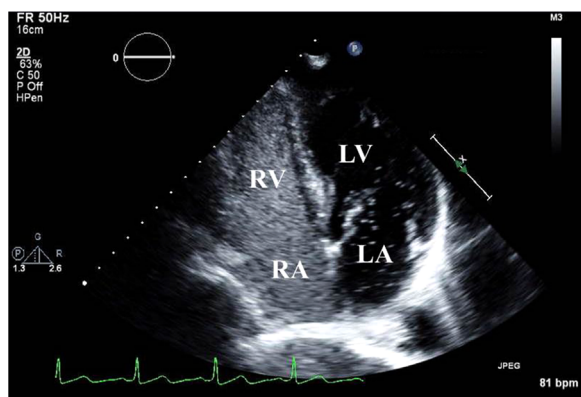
Example of positive contrast study by TTE in a patient with PFO. Microbubbles are visualized filling the right-sided chambers and into the LA and LV. LA, left atrium; LV, left ventricle; PFO, patent foramen ovale; RA, right atrium; RV, right ventricle; TTE, transthoracic echocardiography.
